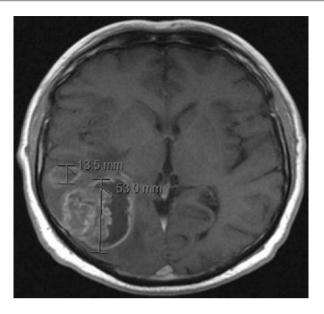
MRI with gadolinium of right occipital glioblastoma
